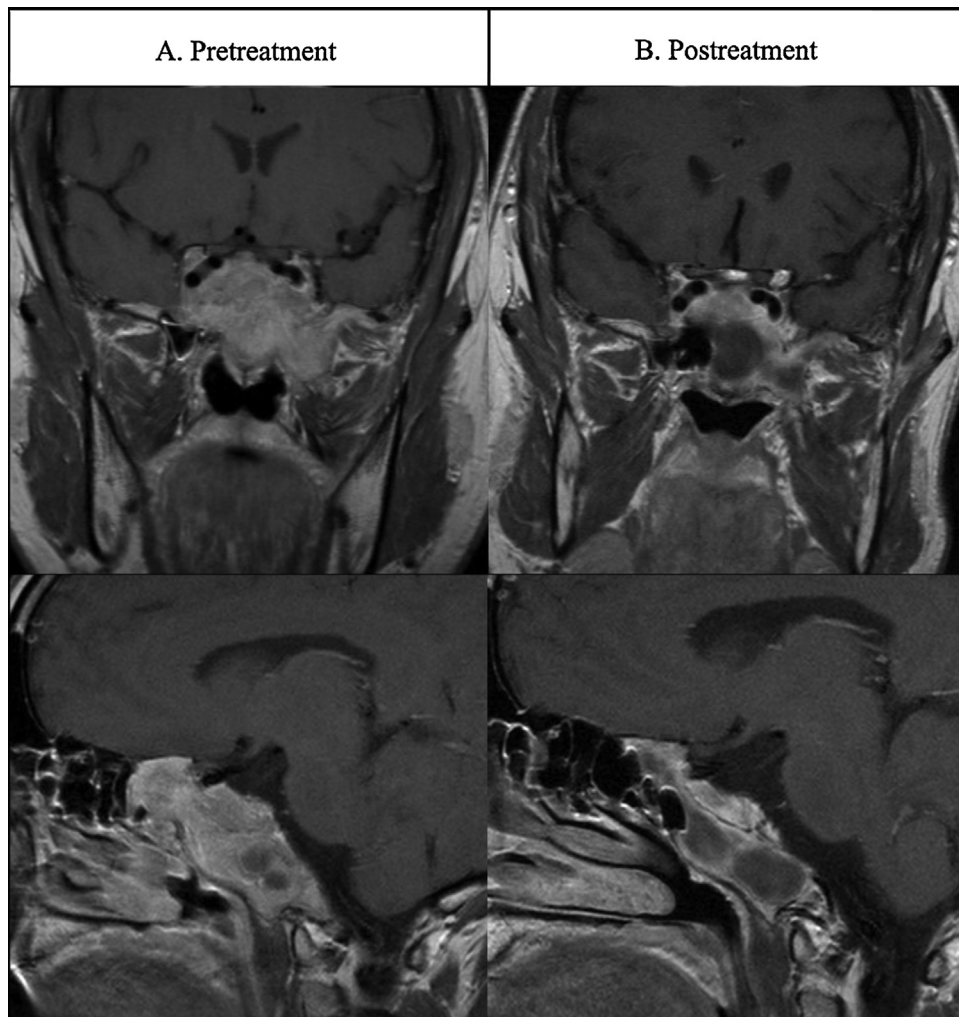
Patient 2's MRI images at presentation and after medical treatment.
